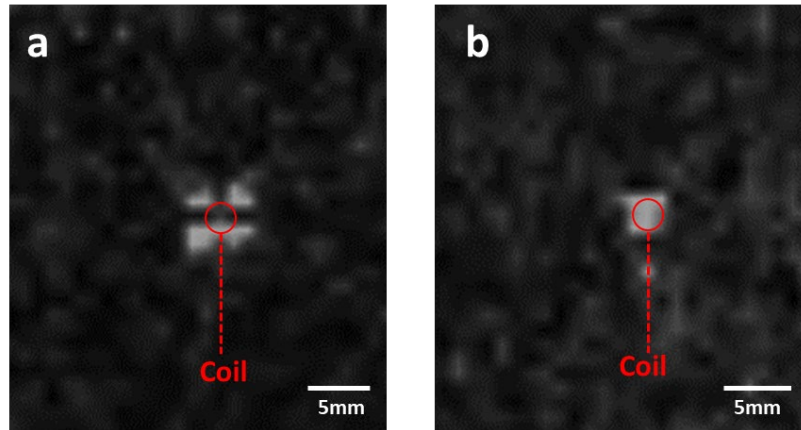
Image of acousto-optic sensor without phase correction (a) and with phase correction (b) under MRI.
